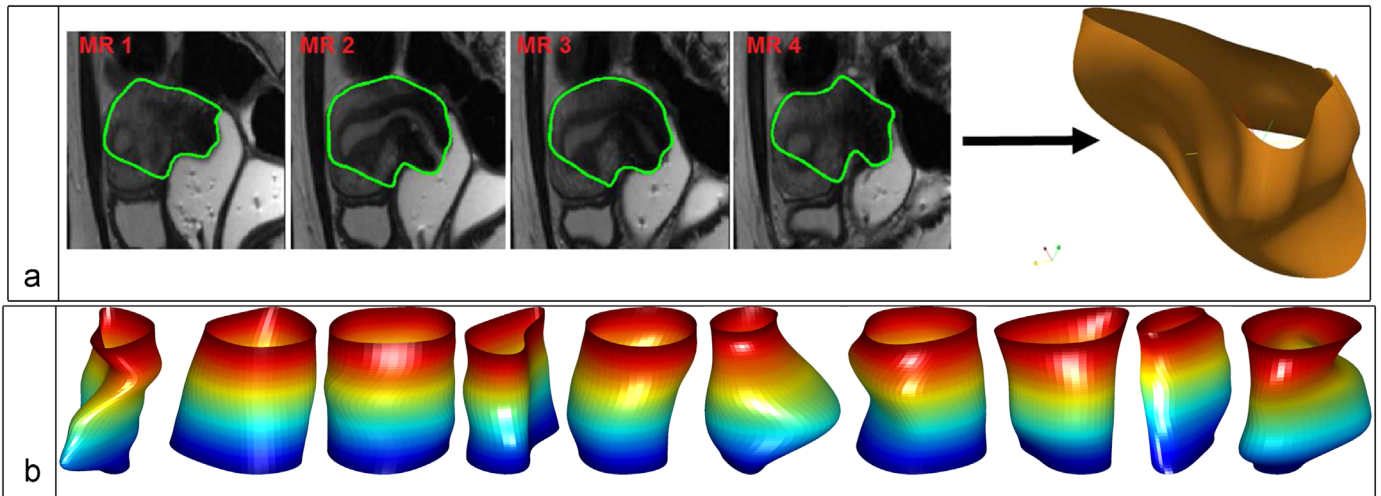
(a) An example of constructing a cylindrical surface using MR image slices. (b) Endometrial tissue surface data from [4] reconstructed using the basis  $\mathcal{B}$ .
